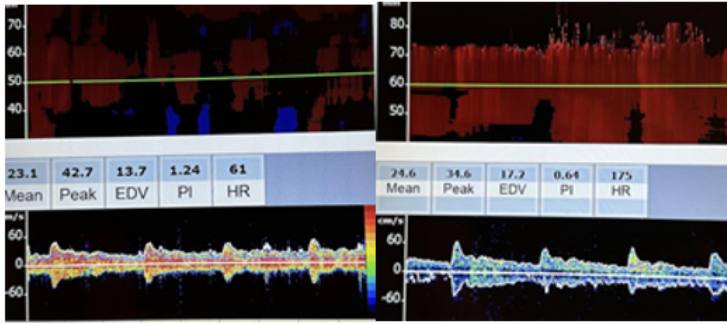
Side-by-side velocities and flow patterns of the right ophthalmic artery and carotid siphon on transcranial Doppler.
